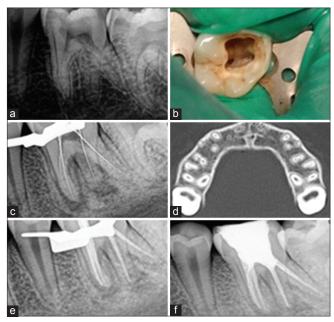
(a) Pre-operative, (b) access opening, (c) working length, (d) spiral computed tomography, (e) master cone, (f) obturation
